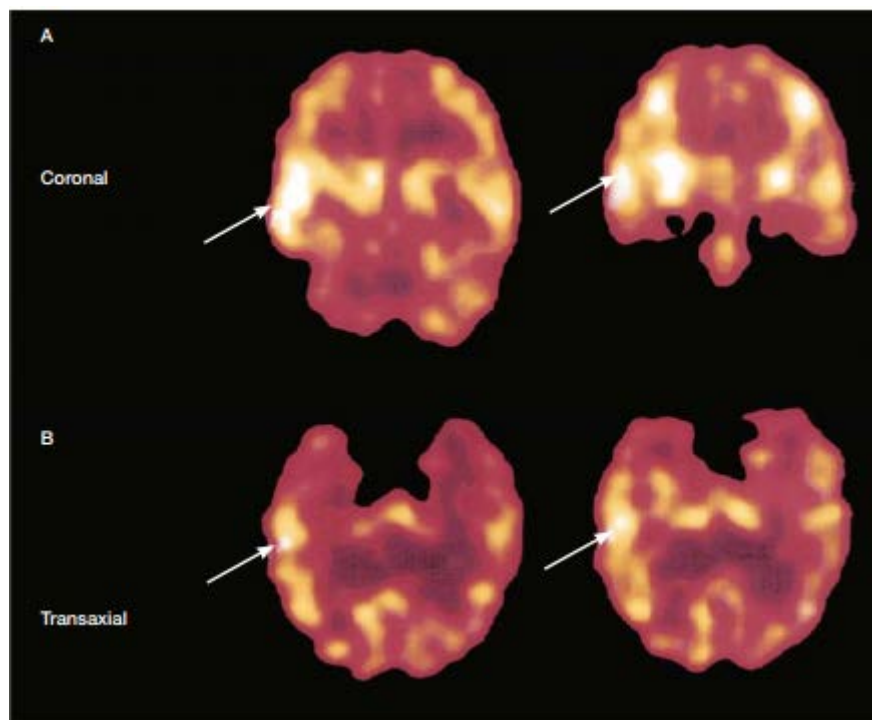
Ictal SPECT shows increased perfusion in the right temporal lobe [3].
